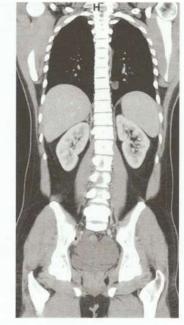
CT scan showing normal kidneys: It gives information about function of kidney. Now more commonly used than IVU
